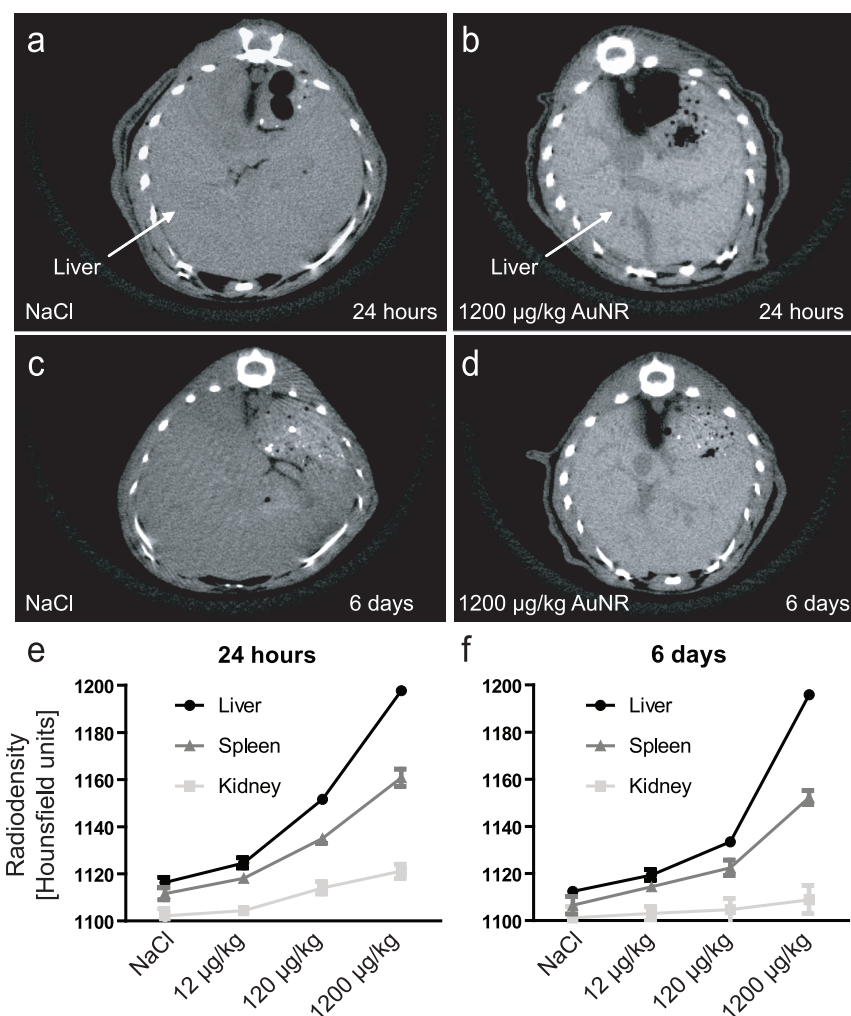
Non-invasive monitoring of AuNR distribution *in vivo*. Microcomputed tomography scans after 24 h of injection of saline (a) or 1200 µg/kg AuNR (b), analyzed using identical imaging settings. The contrast of the liver is enhanced due to AuNR deposition. After 6 days, data appear similar for saline (c) or AuNR treatment (d). Statistical summary of radiodensity quantification after 24 h (e) or 6 days (f) given as Hounsfield units in liver, kidney, and spleen.
